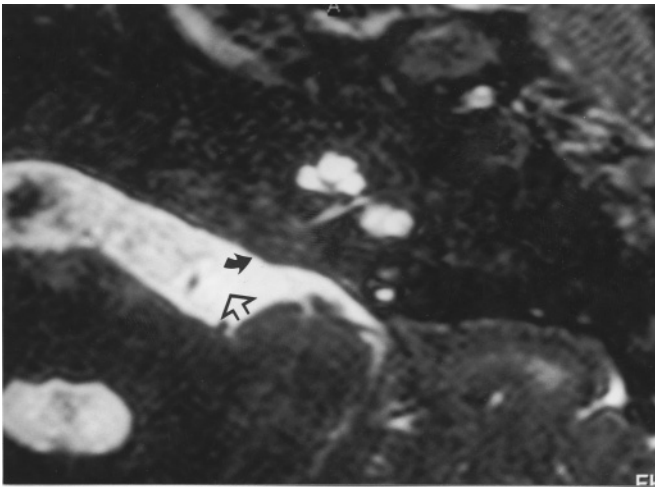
MRI scan showing almost complete agenesis of the internal auditory meatus (solid arrow) and the absence of the cochlear nerve in the cerebellopontine angle (open arrow).
